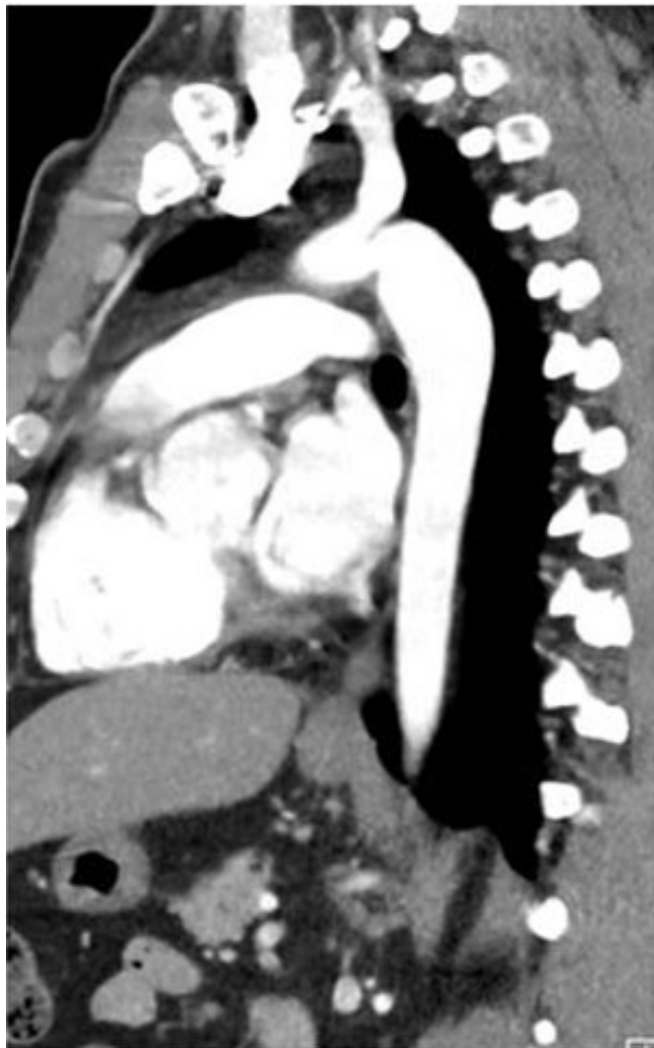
CT demonstrating kinking in the descending thoracic aorta, indicating pseudocoarctation of the aorta.
